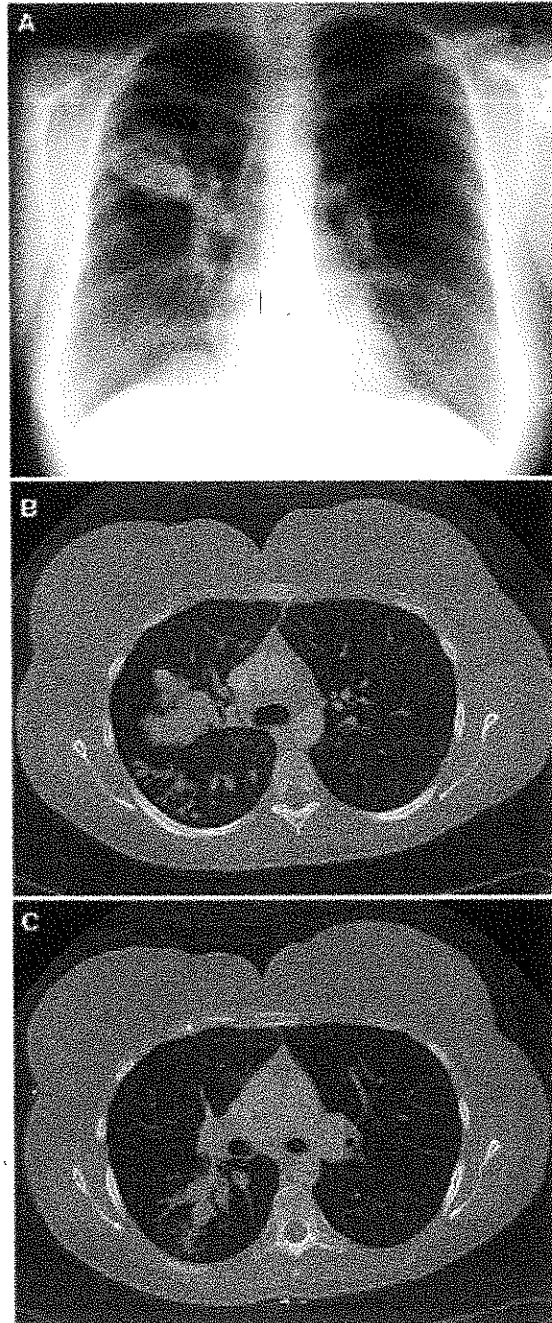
PA and lateral chest radiographs of a woman with ABPA: dense airway filling and parenchymal infiltrate are present. The companion CT images show finger-in glove finding of mucus filled and grossly dilated airways, and findings of bronchiectasis (dilated, thickened and irregular bronchi).
